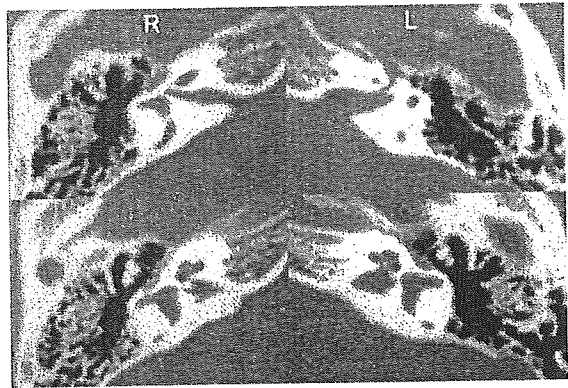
Axial high-resolution CT scans of the internal auditory meatus (IAM). Compared with the normal left IAM (L), the right IAM (R) is much narrower, and shows branching in the IAM.
